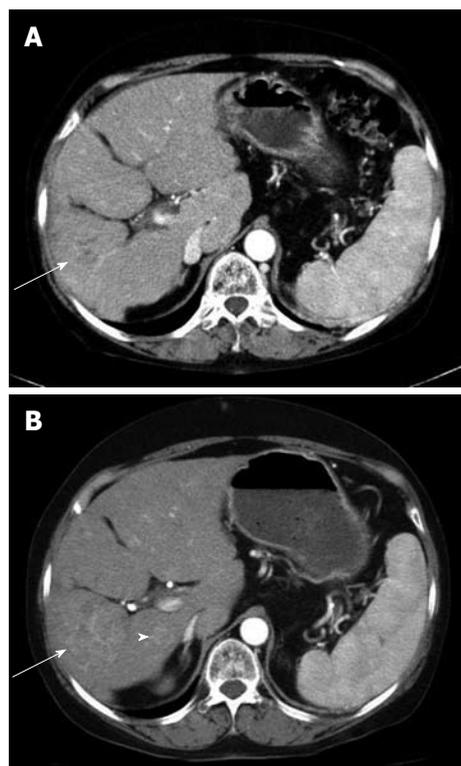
Contrast-enhanced computed tomography scan in arterial phase at the time of diagnosis of initial splenic infarction (A) and 2 mo later (B). A: When splenic infarction was diagnosed, an approximately 4 cm x 4 cm sized hepatocellular carcinoma (HCC) (arrow) was shown in S6; B: Two months later, the size of HCC was enlarged to 5 cm x 5 cm (arrow) and an intrahepatic metastatic nodule was also seen (arrowhead) beside main mass.
